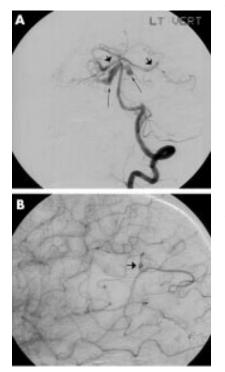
Digital subtraction angiography of the cerebral vessels in a 60 year old woman six years after left atrial myxoma resection. (A) Left vertebral artery arteriogram, transfacial view, shows large irregular fusiform aneurysms of the proximal superior cerebellar arteries bilaterally (long arrows). Involvement of the P1 segment of the right posterior cerebral artery and the more distal left posterior cerebral artery is noted (short arrows). (B) Right internal carotid arteriogram, magnified lateral view, shows a peripheral fusiform aneurysm of a distal posterior right middle cerebral artery branch (short arrow). Thromboembolic events emanating from an aneurysm can result in transient ischaemic attacks, which are radiographically occult. Haemodynamically significant vessel stenosis can cause intermittent ischaemic symptoms. Parenchymal and intraventricular metastases, although uncommon, result in symptoms referable to the area of brain involved and the mass effect they create.
